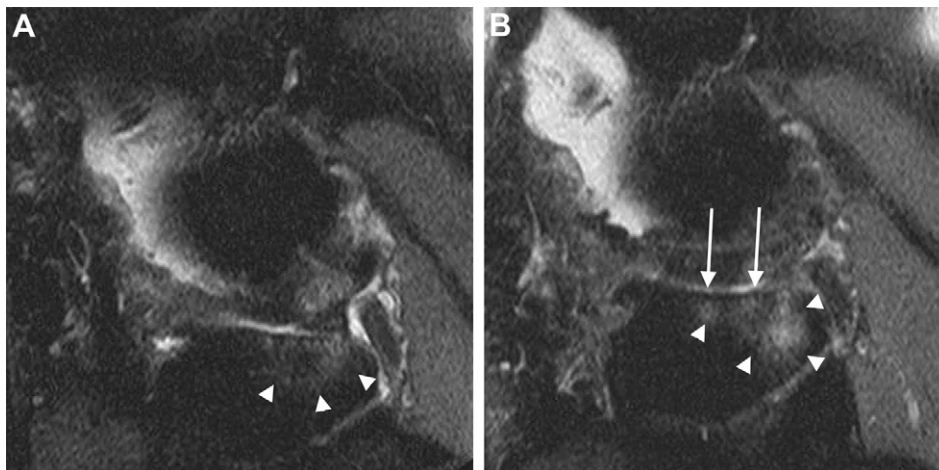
Incident SBA in the lateral tibia. (A). Sagittal fs PDw MRI at baseline shows subchondral bone marrow lesion in the central and posterior subregions of the lateral tibial plateau (arrowheads). (B). Sagittal fs PDw MRI at 30-months follow-up shows incident attrition in the central subregion of the lateral tibial plateau. Also note progressive adjacent subchondral bone marrow lesion (arrowheads).
